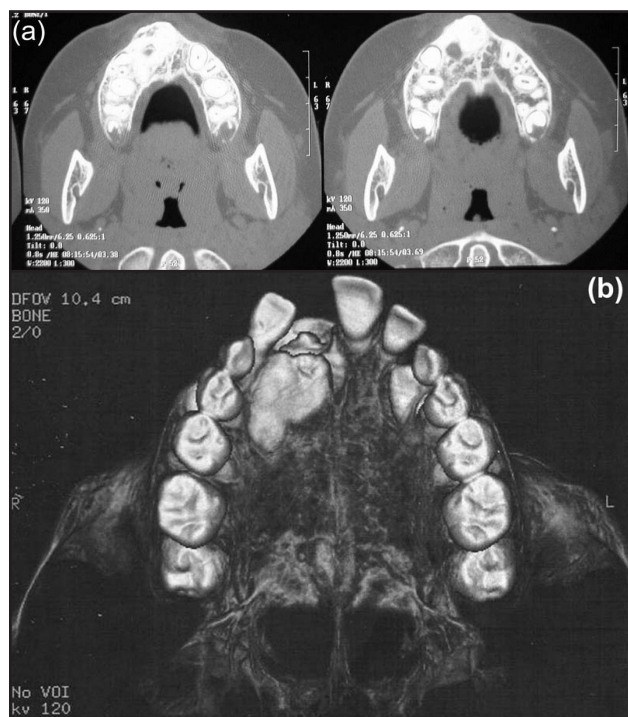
(a) Axial 2-dimensional computed tomography scan showing a hyperdense lesion in the anterior alveolar ridge. (b) Three-dimensional CT scan showing an inferior superior view with an irregular circumscribed lesion in the hard palate.
